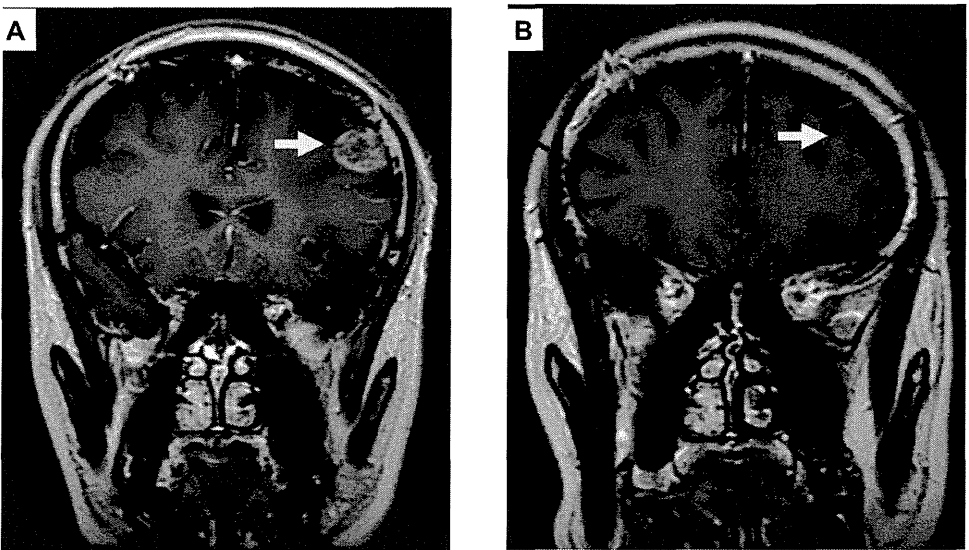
Pre (A) and post (B) treatment brain magnetic resonance imaging of metastatic tumor showing a complete response (arrows).
